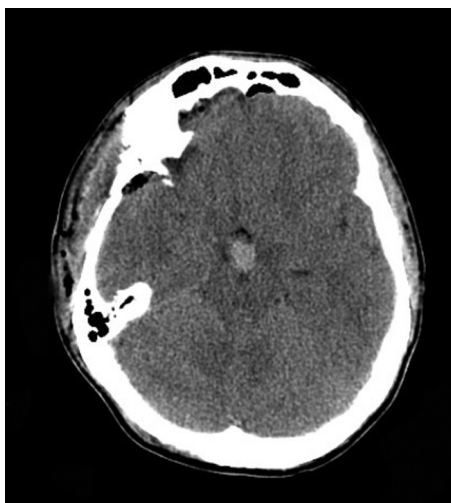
The postoperative computed tomography (CT) scan demonstrated no data of surgical complications.
